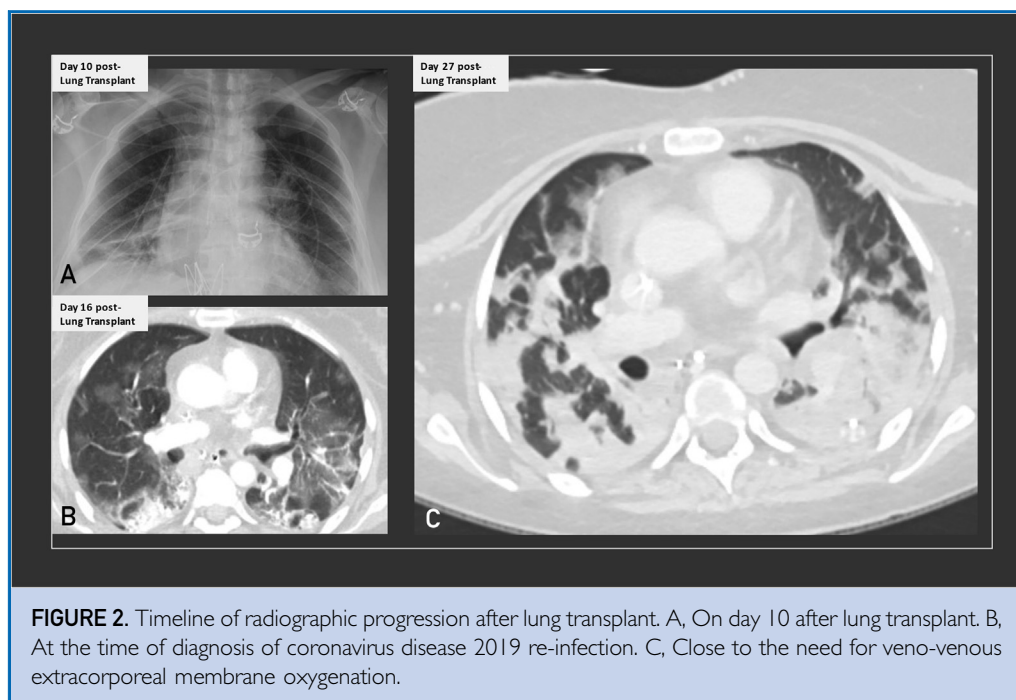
Timeline of radiographic progression after lung transplant. A, On day 10 after lung transplant. B, At the time of diagnosis of coronavirus disease 2019 re-infection. C, Close to the need for veno-venous extracorporeal membrane oxygenation.
